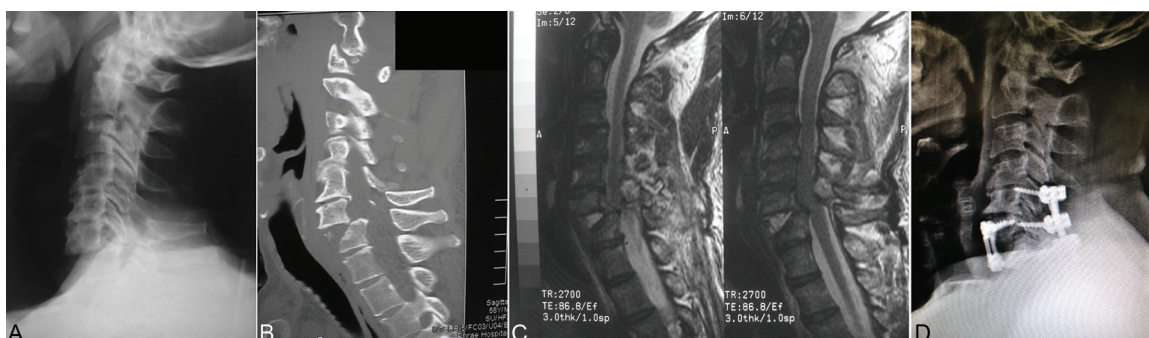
Old/delayed bilateral facet dislocation with myelopathy (case No. 8). A) Lateral view of the cervical spine showed old bilateral C6-C7 facet dislocation. B) CT scan showed anterior translation C6 over C7 with posterior element fracture. C) MRI showed spinal cord compression without intervertebral disc herniation. D) Combined posterior-anterior fixation was performed.
